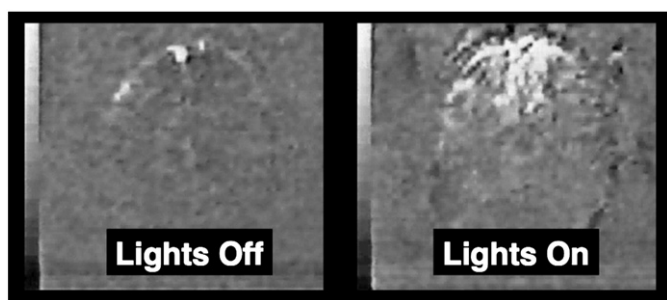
MR images from the data of Ken Kwong, as presented by Tom Brady at the 1991 ISMRM meeting. On the left, one frame of the movie taken when the photic stimulation was off; on the right, one frame of the movie taken when the photic stimulation was on.
